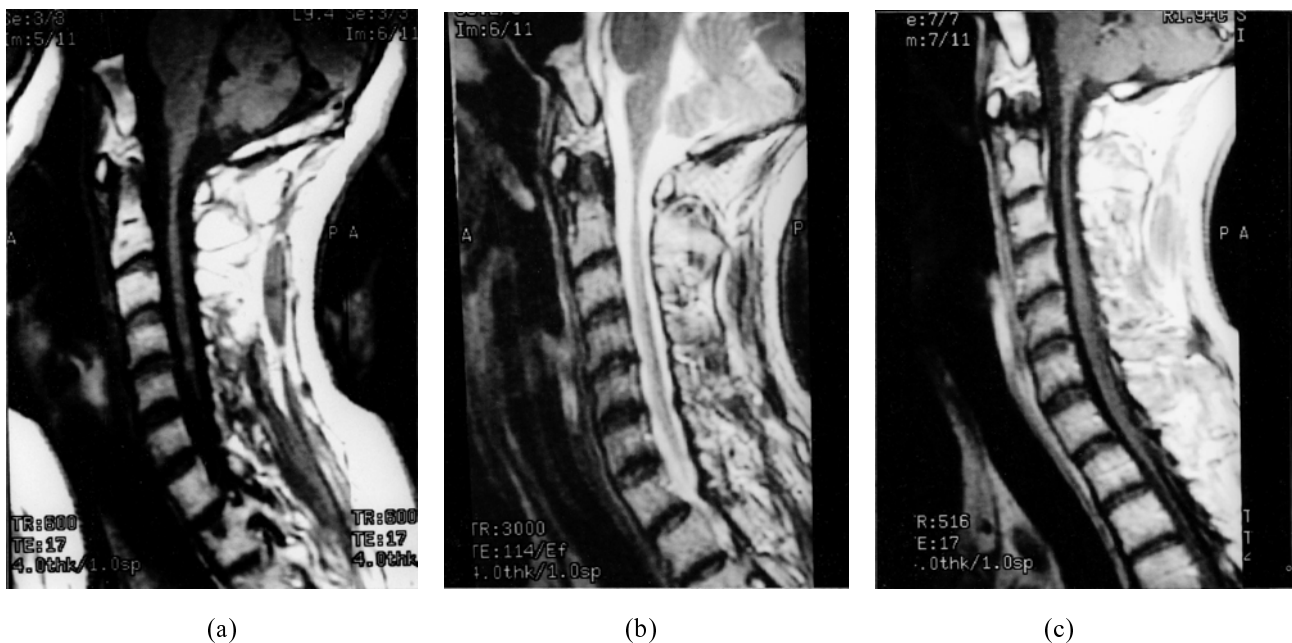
C-spine MRI in May 2001. a-c: Similar findings compared with that of previous MRI (Figure 2) but much more remarkable cord atrophy was demonstrated.
